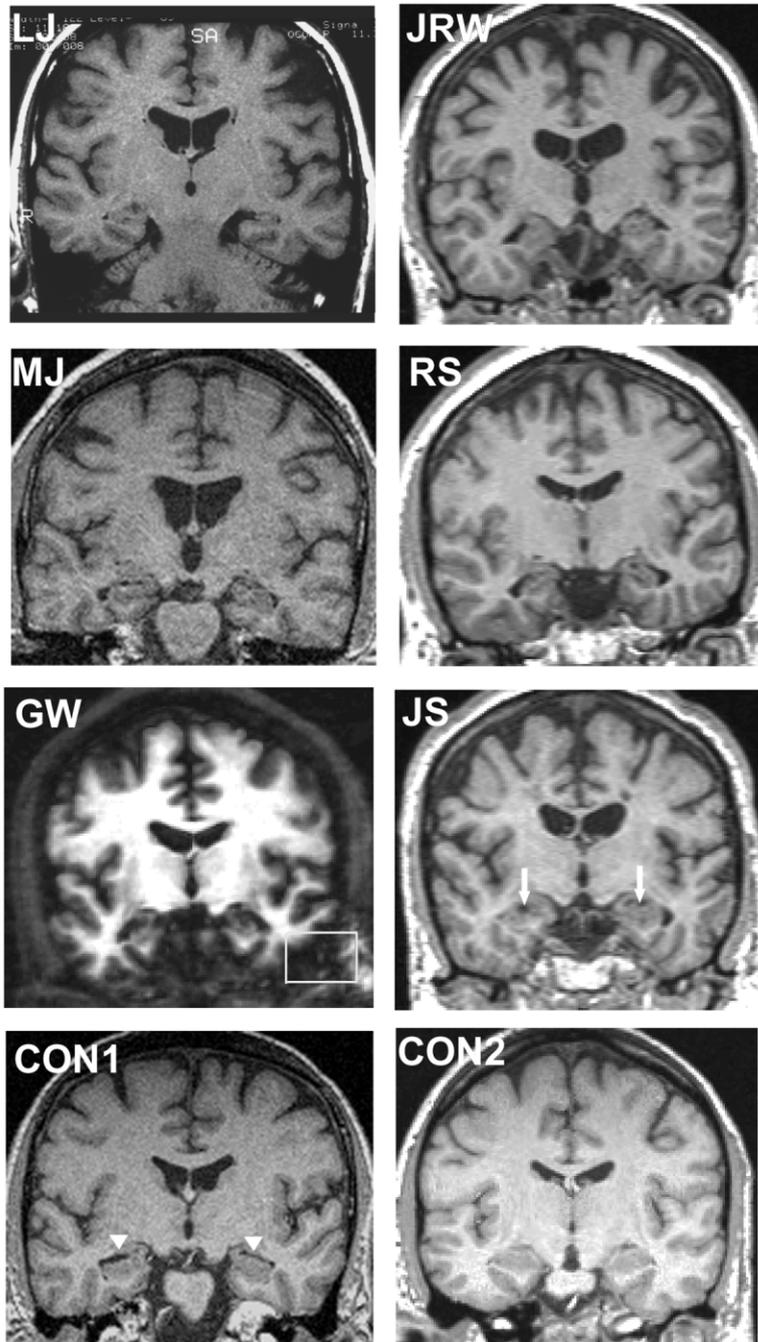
Magnetic Resonance Images for Six Amnesic Patients with Damage Limited Primarily to the Hippocampal Region and Two Healthy Controls
